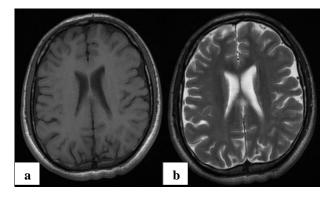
Axial brain T1 (a) and T2 (b) MR imagings of the patient.
